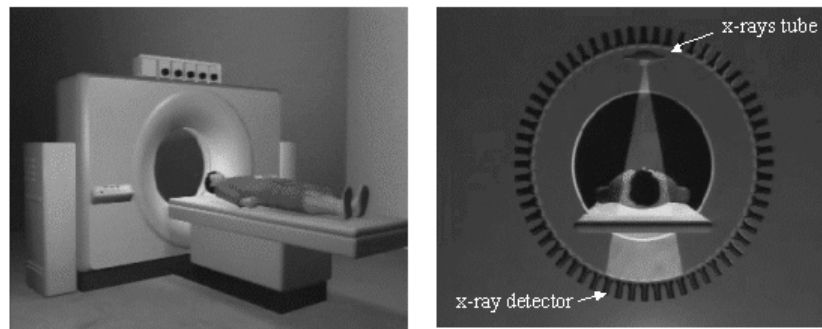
An x-ray computed tomography unit. As the x-ray tube rotates, a fan-beam of x-rays is scanned across the patient to acquire a projection that is made up of a large number of rays transmitted through the body. (Image courtesy of Curriculum Development Institute of Hong Kong)
